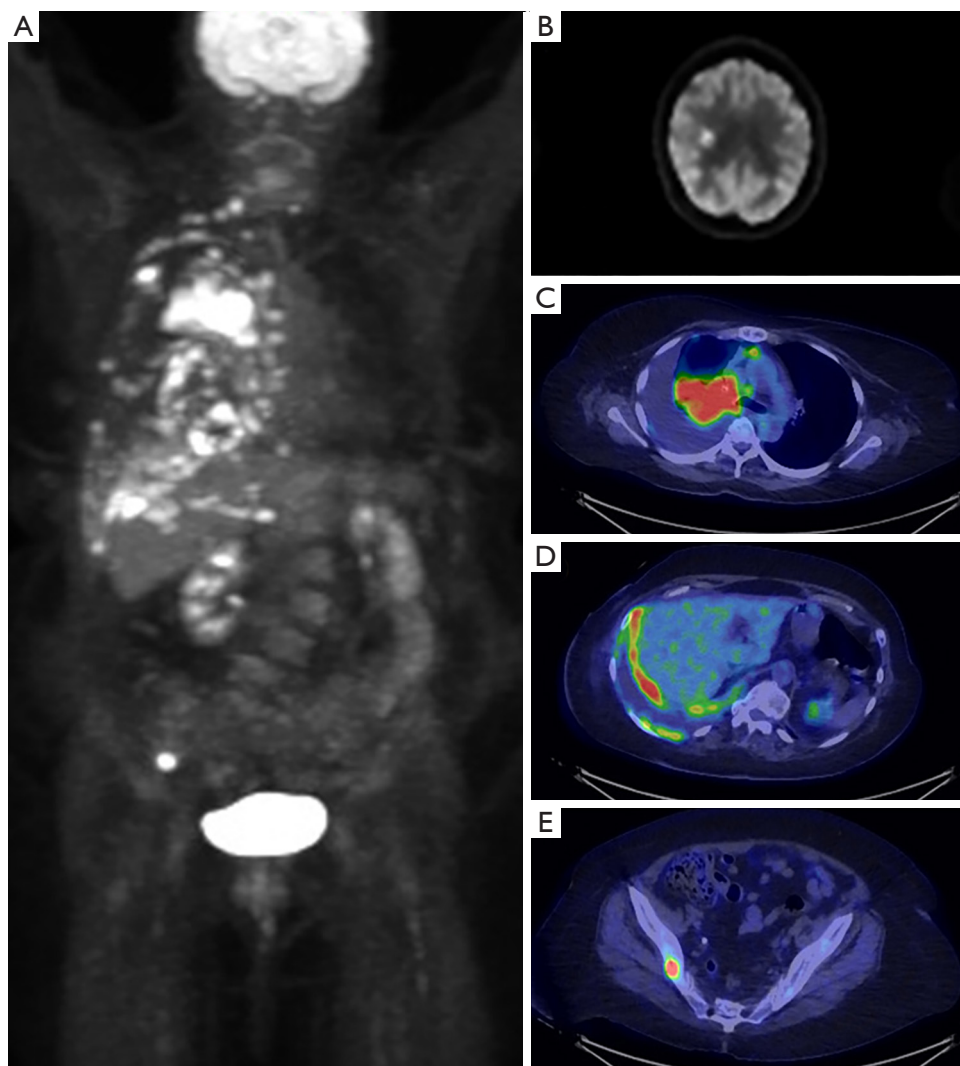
A 73-year-old female presenting for initial staging of NSCL demonstrating the utility of FDG PET/CT. MIP reconstruction (A) demonstrates widespread metastatic disease. Axial fused PET/CT images show: hypermetabolic right brain metastasis (B), hypermetabolic primary right upper lobe malignancy (C), right pleural metastasis (D) and right iliac bone metastasis (E).
